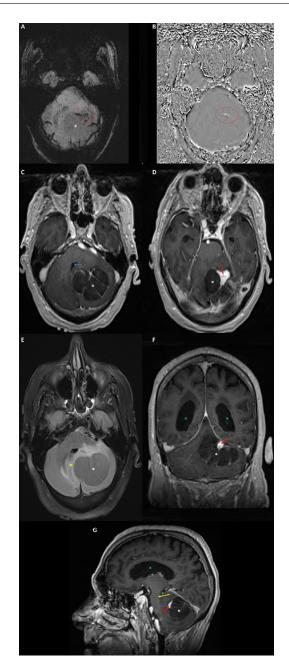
Multiplanar MR imaging of the brain redemonstrating a large cystic lesion with thin septations in the left aspect of the cerebellum (white asterisk; A-G). SWI and phase imaging sequences demonstrate increased signal in the anterior aspect of the lesion, suggesting hypervascularity (red circle; A, B). T1-weighted imaging with contrast demonstrates effacement of the fourth ventricle (blue arrow; C) and redemonstration of the mural nodule (red arrow; D). The cystic lesion was associated with surrounding edema (yellow asterisk; E) on the T2/FLAIR imaging sequence. Coronal (F) and sagittal (G) planes using T1-weighted imaging with contrast demonstrate a mural nodule (red arrow; F, G), bilateral lateral ventricle hydrocephalus (green asterisks) and mass effect on the left aspect of the brainstem, including the inferior midbrain and left posterolateral pons (yellow arrow; G) (Color version of the figure is available online.).
